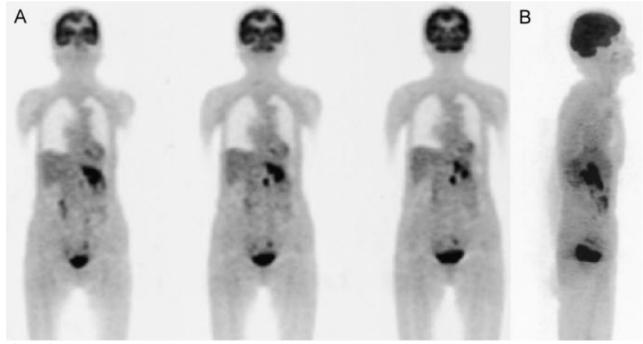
87 year old woman with neoplastic meningitis from gastric cancer. FDG PET showed deoxyglucose uptake in the stomach and the head of the pancreas (A). No deoxyglucose uptake was apparent in the spinal canal on FDG PET (B).
